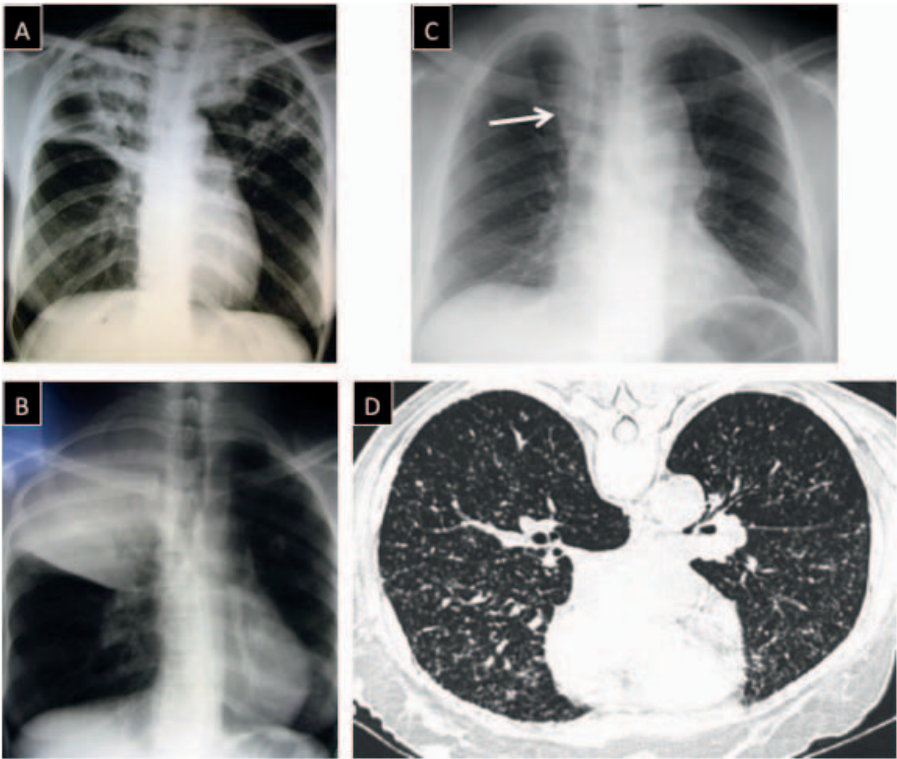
Cavitatory bilateral upper lobe consolidation (A). Right upper lobe consolidation with air bronchogram (B). Right para-tracheal lymphadenopathy with normal lung parenchyma (C). Miliary TB pattern on CT scan (D).
